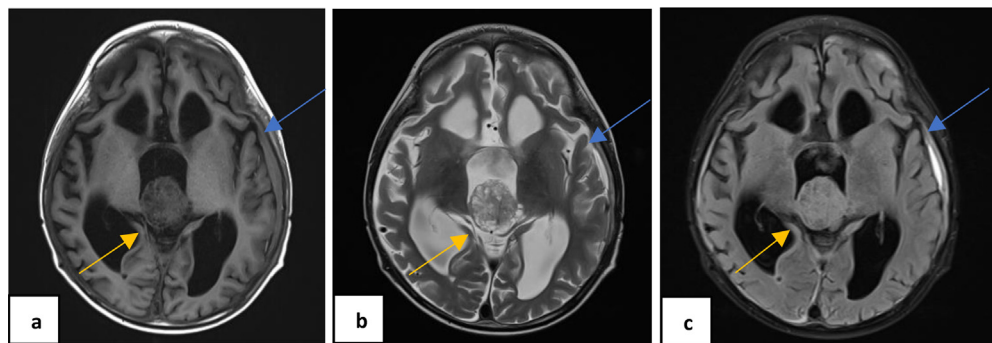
The MR Imaging showed a mass (yellow arrow) in third ventricle with hypointense signal on T1W1 (A), slight hyperintense signal on T2W1 (B), no suppression on T2-FLAIR (C) and subdural hygroma (blue arrow).
